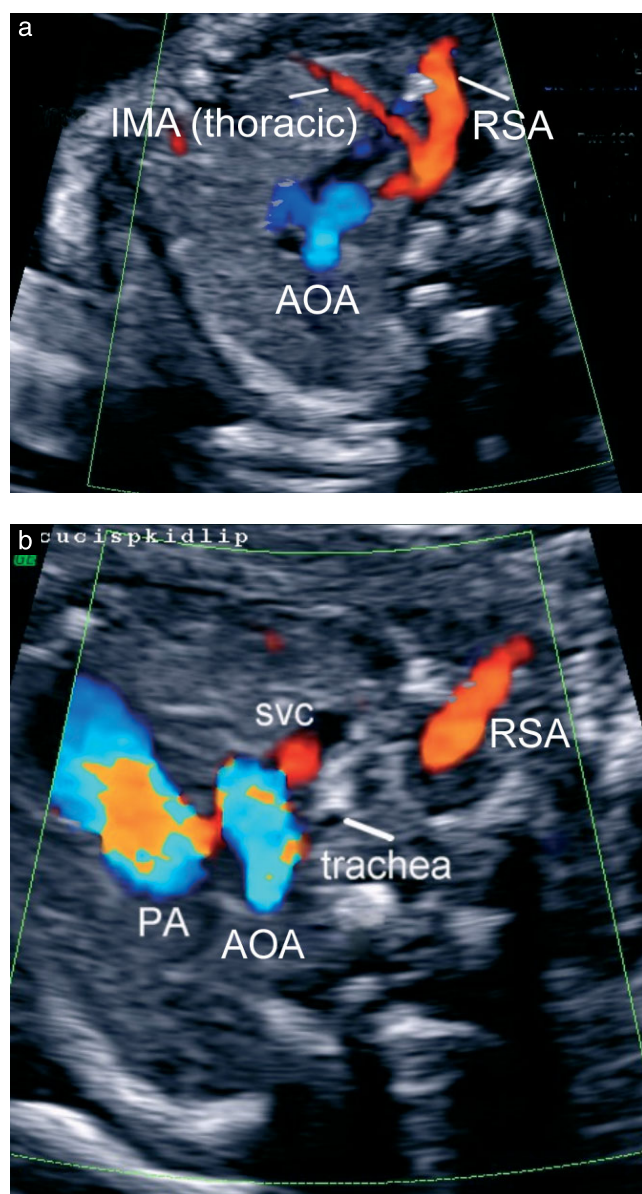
Direct visualization of the right subclavian artery (RSA) with (a) or without (b) the internal mammary artery (IMA) by color Doppler imaging. AOA, aortic arch; PA, pulmonary artery; SVC, superior vena cava.
